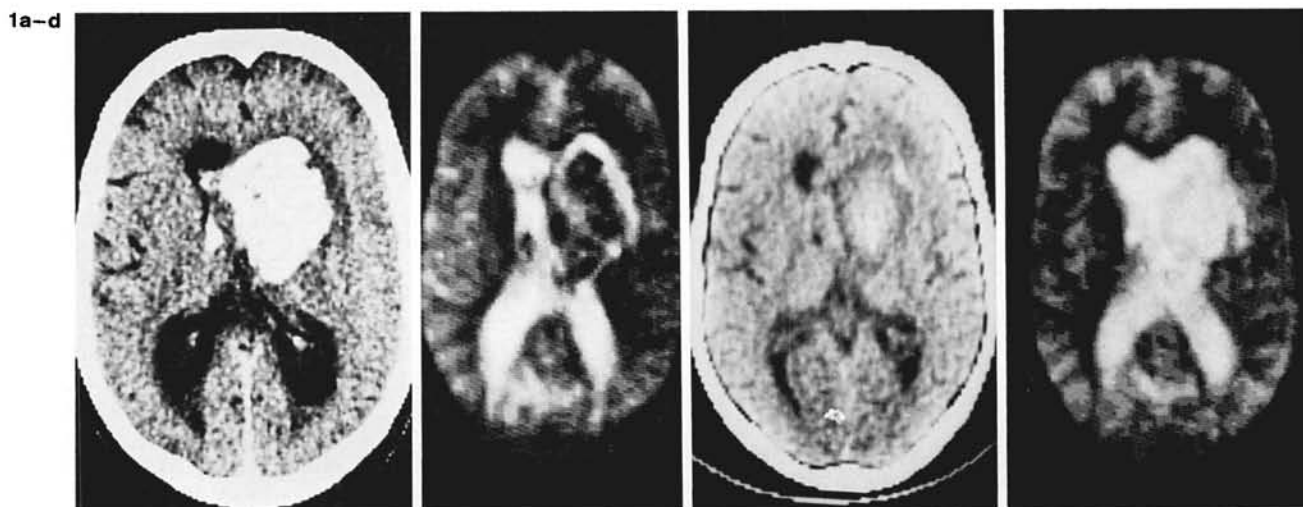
Intracerebral hematoma imaged 2 days after the onset of symptoms on noncontrast CT scan (a) and at 0.17 T with the spin echo 2,000/160 sequence (b). The same section was reimaged at 8 days (c and d).
